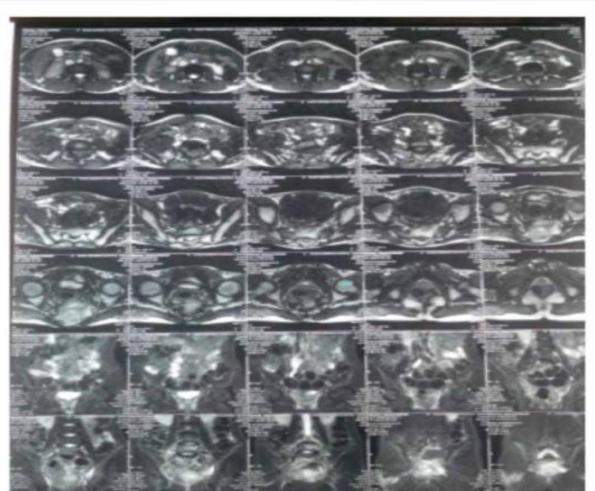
MRI post radiotherapy
